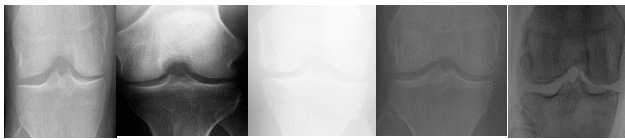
Similar Knee X-ray images corresponding to Grade 2 (Minimal knee Osteoarthritis).
